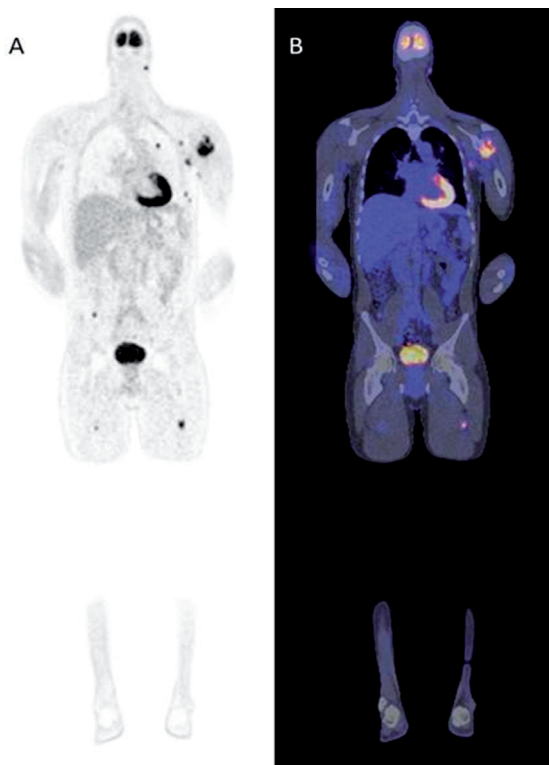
Images of FDG-PET (A) and FDG-PET/CT (B) of a melanoma patient with distant metastases in lung, bone, muscle, and subcutaneous tissue
